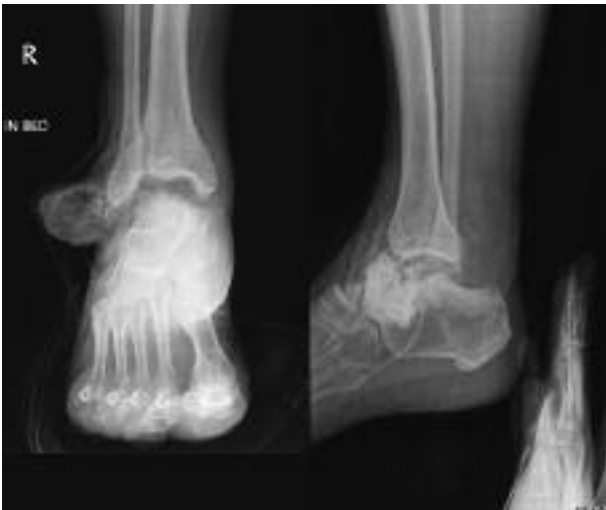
Case 2 : initial radiograph
